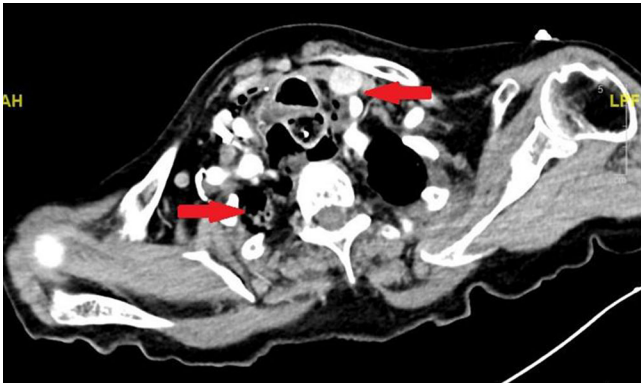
◀ Computed tomography (CT) scan in the transverse plane of the thoracic region of the patient showing the mediastinal emphysema with air inclusions (arrows), 1 day after perforation
